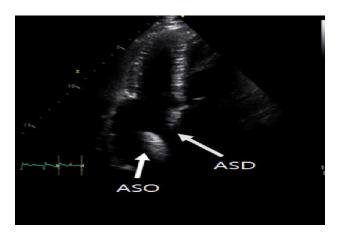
Echocardiography showing atrial septal defect (ASD), atrial septal occluder (ASO) and device migration into the left atrium.
